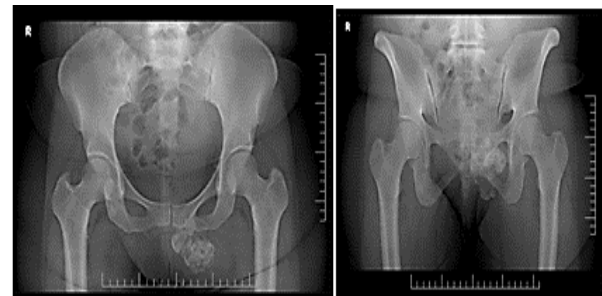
Preoperative X-ray showing the inlet and outlet views of the pelvis showing the osteochondroma
